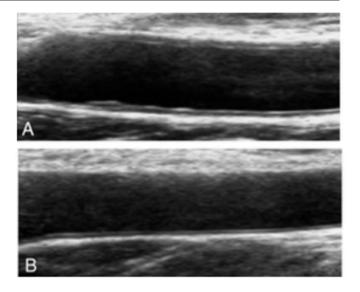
(A) US picture of the carotid intima-media from the hypertension research group. (B) Ultrasound picture of the control group's carotid intima. (C) Group Comparison. Hypertension is indicated by HP.²²
